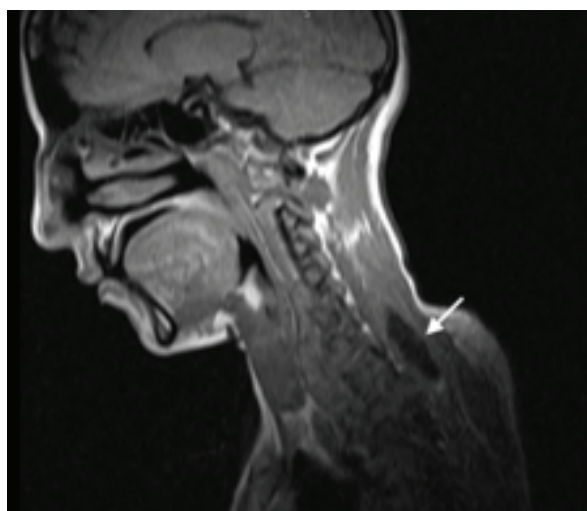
Cystic lesion showing hypointensity on T1-weighted sequences
